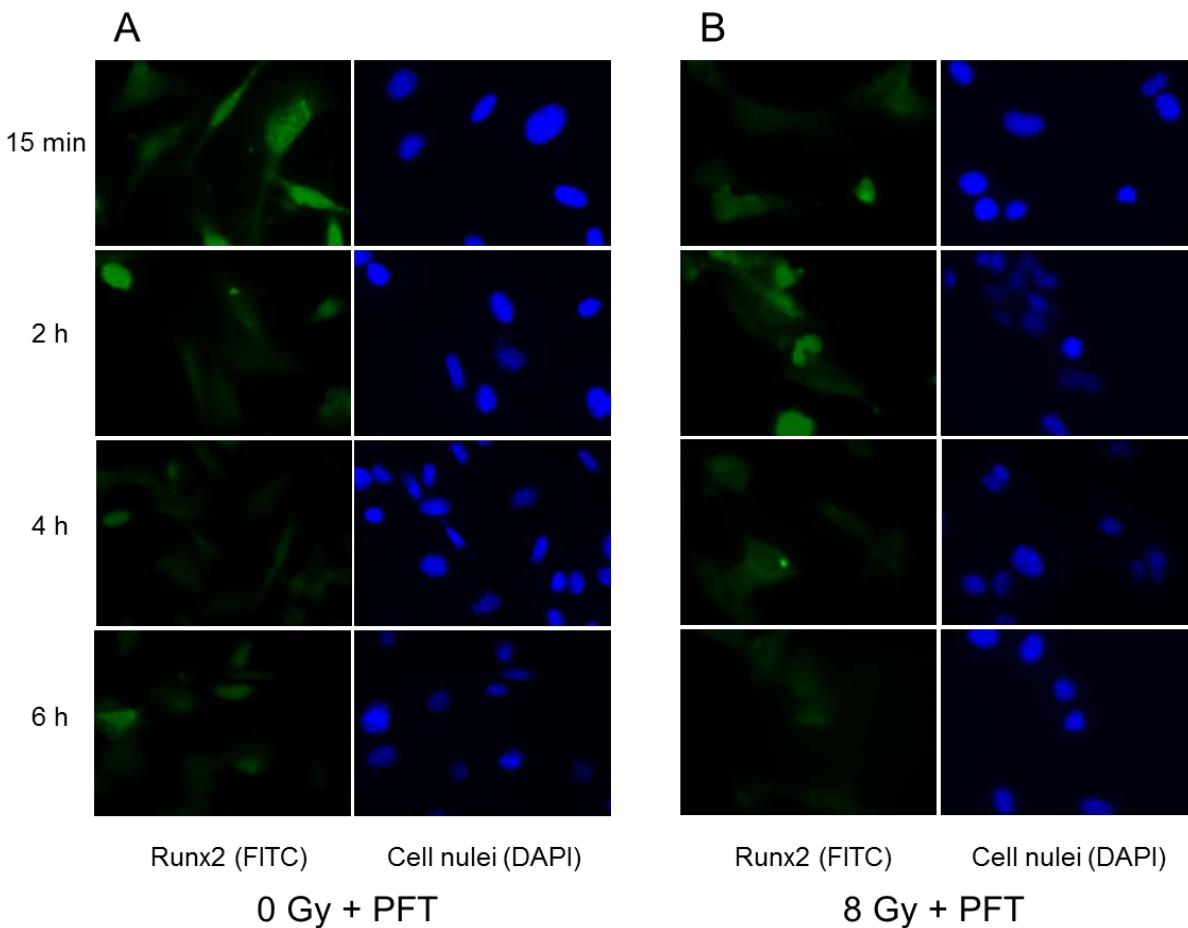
Runx2 expression in OCT-1 cells after X-ray exposure in presence of cyclic pifithrin- α
